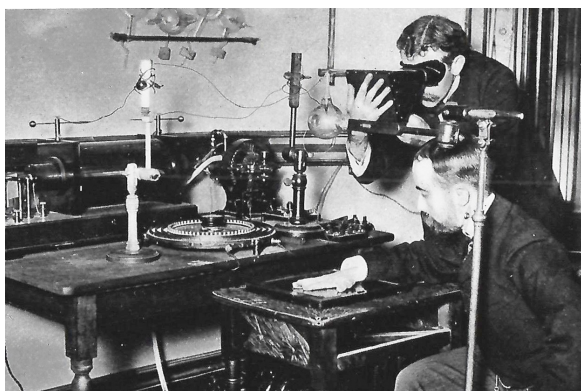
Morton's X-ray apparatus arranged for simultaneous radiography and fluoroscopy [6]
